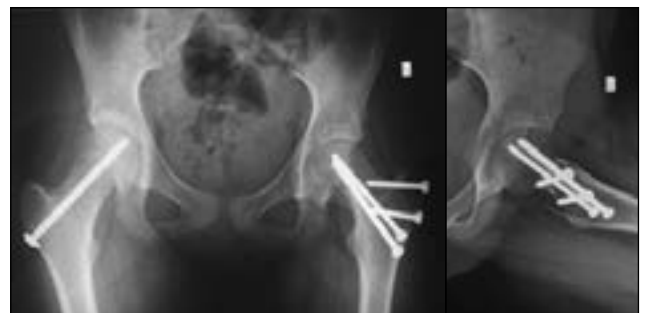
At 9 months after open reduction of the left hip X-Rays show the correct axial anatomic relations without signs of femoral head necrosis. The right hip was stabilized prophylactically by a transfixing screw
